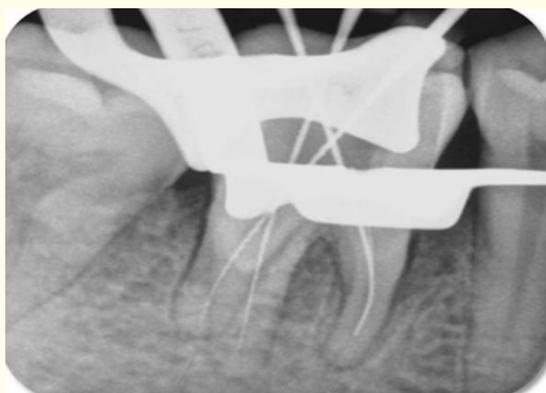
Working length IOPA radiograph of tooth #46 with distal angulation.
